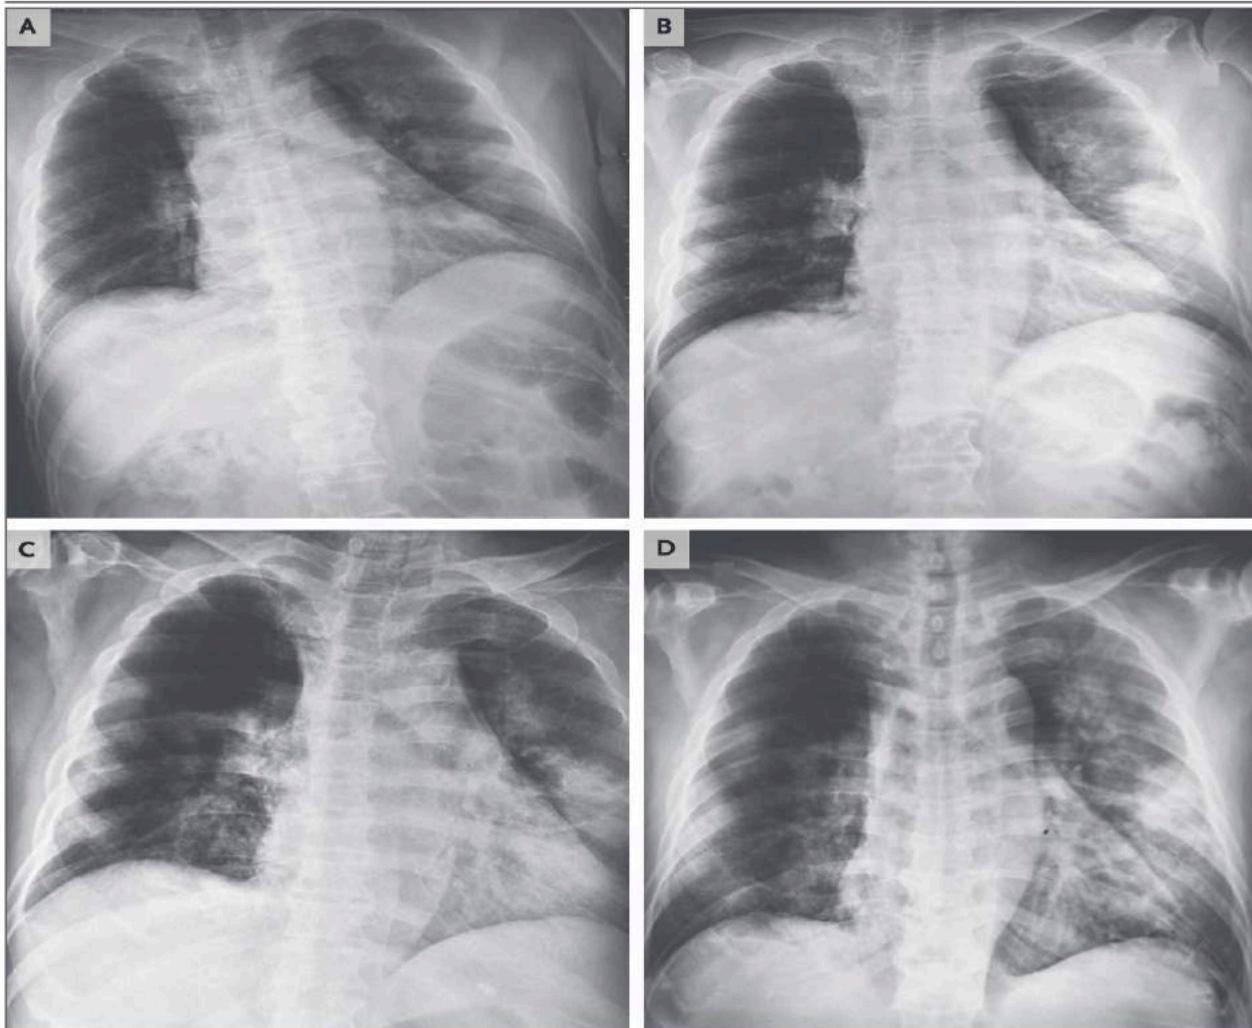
Radiographs of the Father's Chest.
